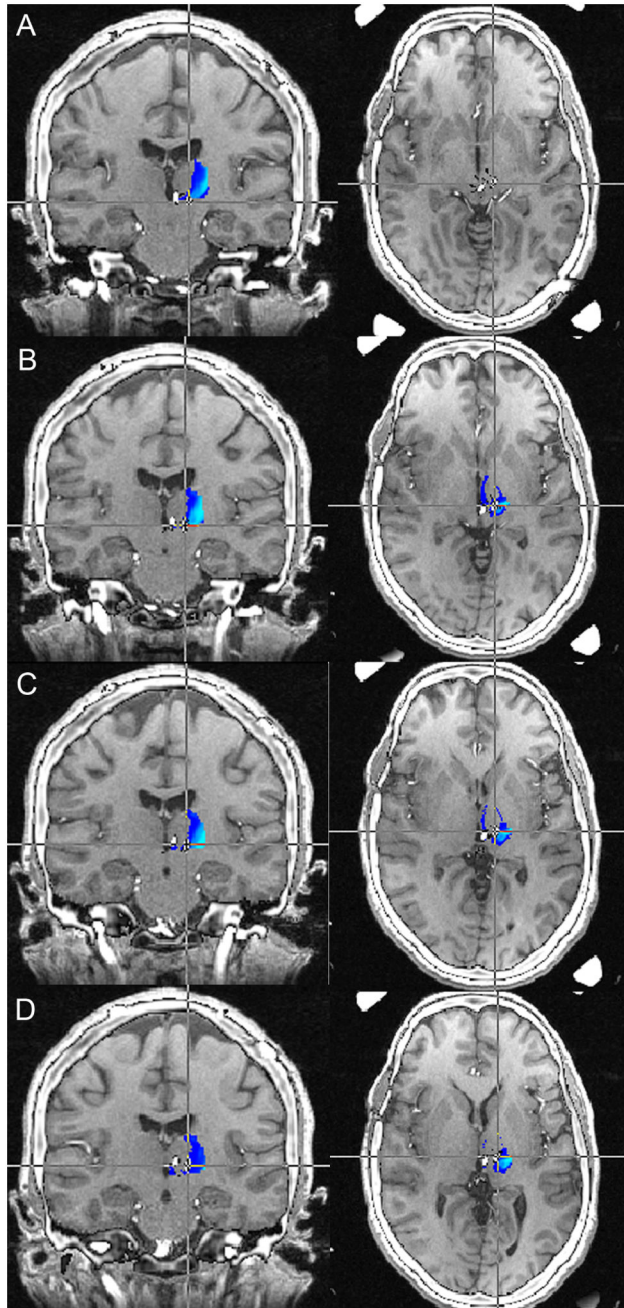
Preoperative MRI-postoperative CT fusion for Patient 3. The probabilistic tractography determined sensory thalamus is shown in blue-light blue, with light blue indicating regions with the greatest probability of being sensory thalamus. Each set of images represents a specific lead position, with A=0, B=1, C=2, and D=3. The patient had the greatest clinical response to contacts 1 and 2 (B and C), with noted greatest overlap with the light blue regions with these lead positions.
